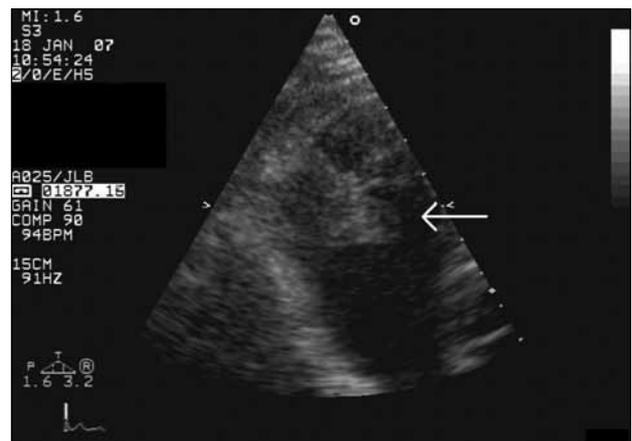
A transoesophageal echocardiogram showing a mildly echogenic 1.2 x 2.4 cm mass lesion (arrow) adhering to the wall of the right ventricle.
